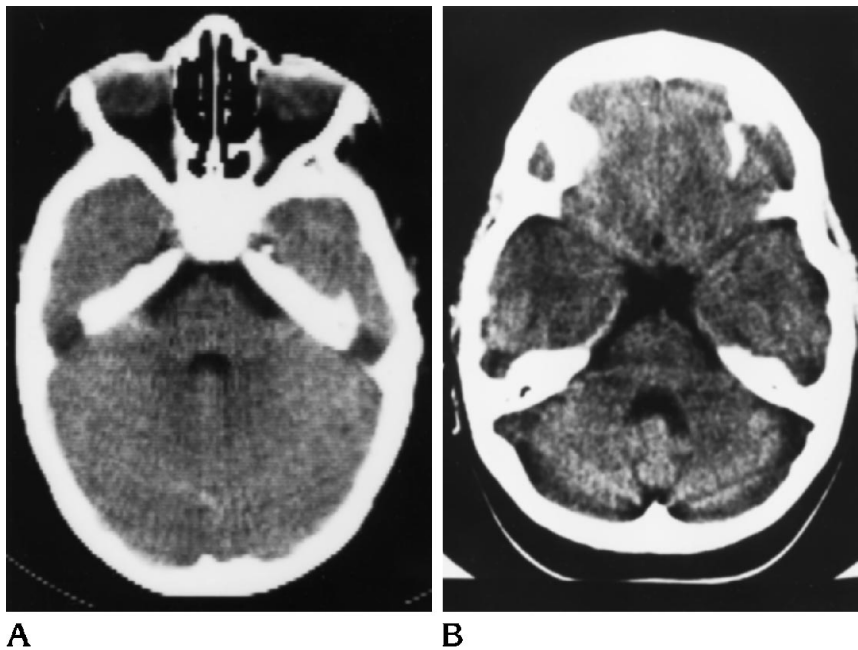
A, CT study of patient 12 at the age of 3 years shows a normal appearance of the cerebellum.
